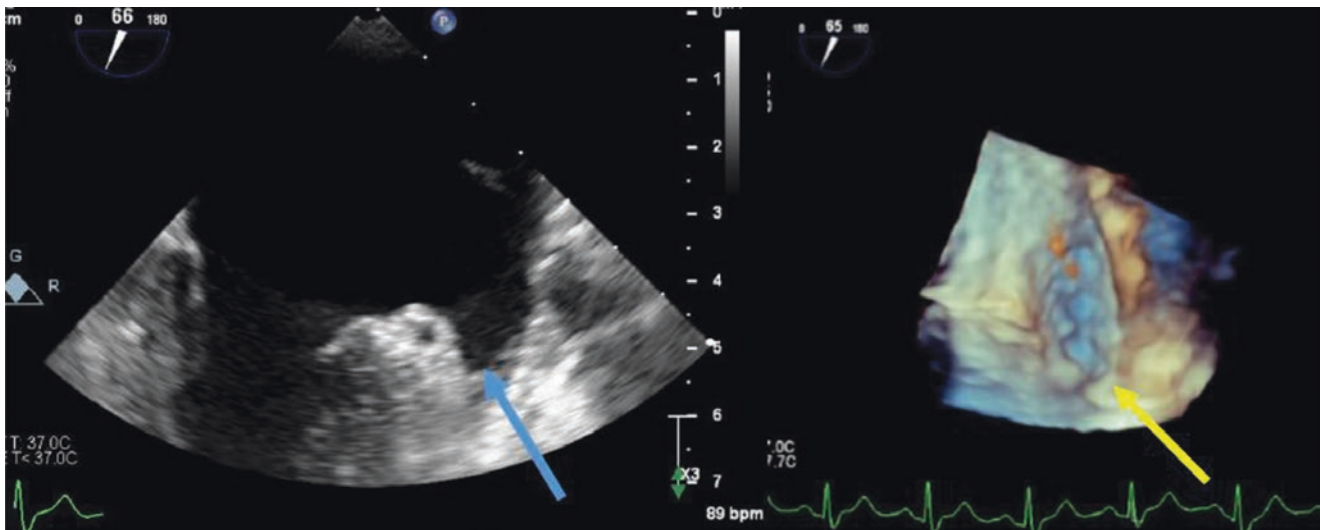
2D transesophageal echocardiography (TEE) of the left atrial appendage showing echoes suspicious for thrombus (yellow arrow) and corresponding 3D TEE confirming that the suspicious “mass” is in fact part of the wall of the appendage (blue arrow)
